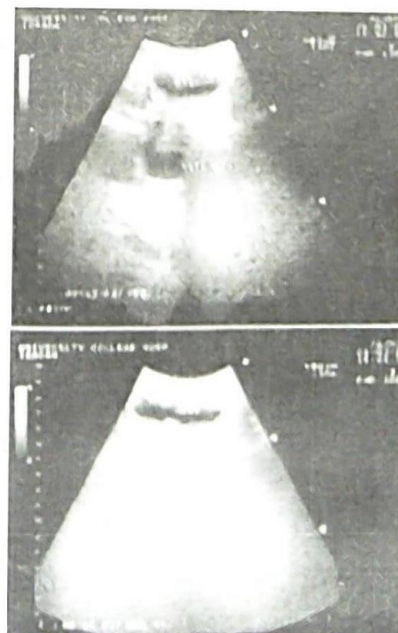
Abdominal ultrasound scan showing an anterior abdominal wall mass seen to communicate with the stomach
